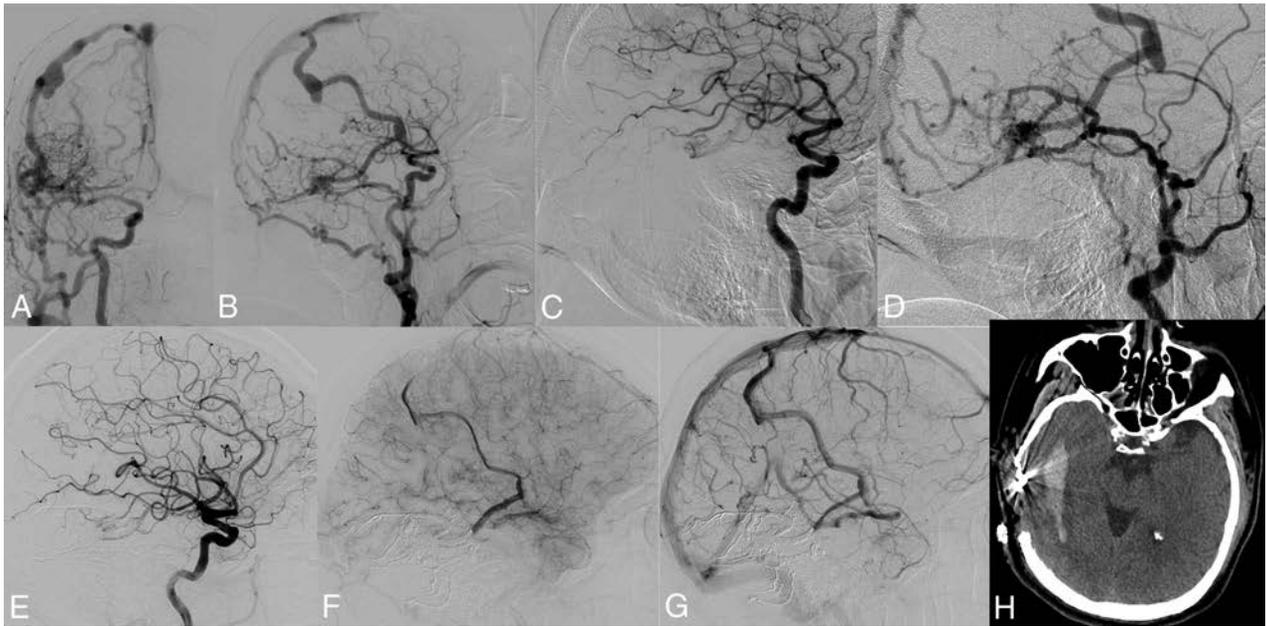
Postoperative parenchymal hemorrhage and possible venous infarction following surgical ligation of a residual DAVF. A middle-aged man had intermittent speech arrest and multiple headaches for several years. Anteroposterior (A) and lateral (B) angiograms demonstrate a variant-type right transverse-sigmoid sinus junction Borden-Shucart grade III DAVF supplied by dural branches of the external carotid artery and pial branches of the MCA (C) with retrograde drainage to the vein of Labbé (D), that anastomatically drains to the vein of Trolard. Following Onyx embolization of the dural external carotid artery branches, only the pial MCA supply to the fistula continued to drain to the cortical vein as demonstrated on early (E), mid (F), and late (G) images from a lateral ICA angiogram. During surgical ligation of the residual DAVF, extensive intraoperative bleeding was noted. A CT performed immediately postoperatively (H) demonstrates right temporal intraparenchymal hemorrhage. The patient did not have a new neurologic deficit postoperatively.
